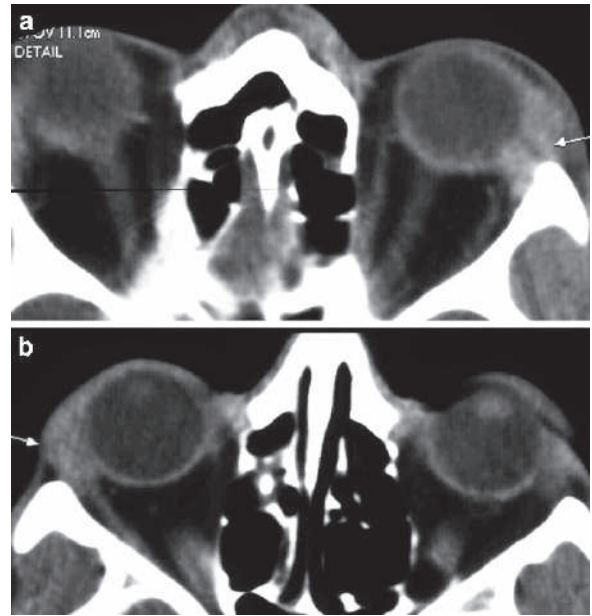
Sequential nonenhanced orbital CT images of the same patient with Sjögren syndrome (SS) show bilateral lacrimal glands enlargement (arrows)
